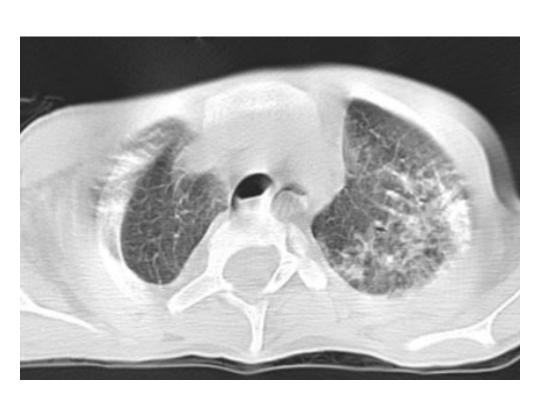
chest CT of patient number 10
